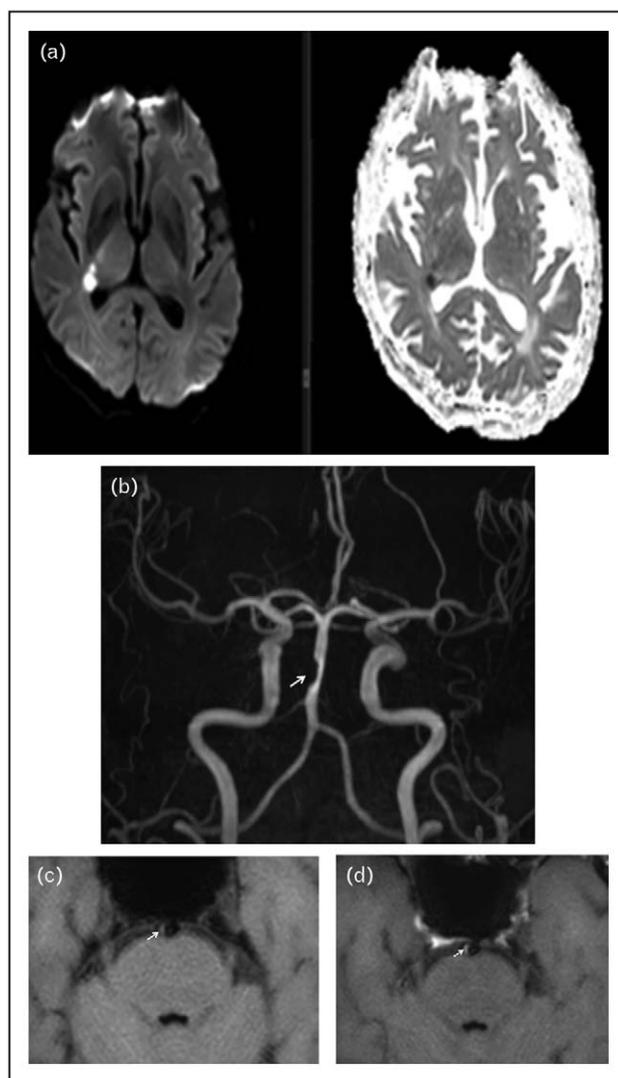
Atherosclerotic plaque. (a) A 65-year-old male patient presented with features suggestive of a stroke. Diffusion weighted imaging shows acute infarctions within the right thalamus and posterior limb of the internal capsule. (b) Time-of-flight magnetic resonance angiography shows focal narrowing of the mid-basilar artery. (c) Vessel wall MRI shows eccentric thickening of the basilar artery wall with intermediate signal intensity. (d) Contrast-enhanced vessel wall MRI shows enhancement of the plaque.
